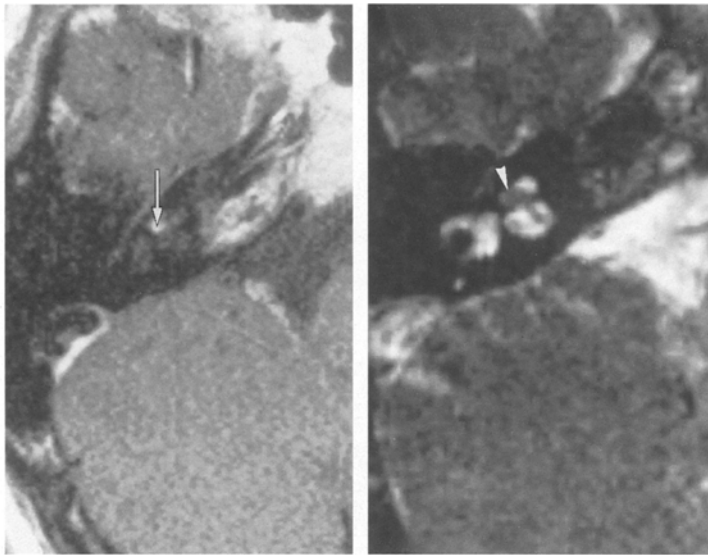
a, b. Vertigo post stap edectomy. Both a CT and b thin T2WI MR depict the intravestibular location of the medial part of the device (*arrow*). The normality of the endo/perilabyrinthine fluid is attested only by MR
